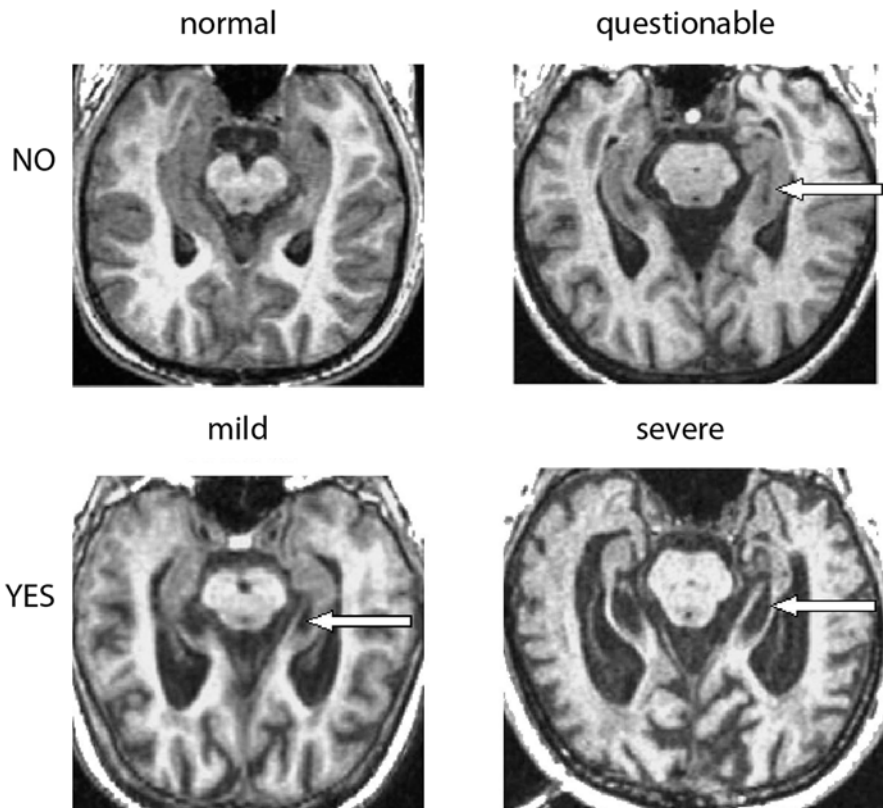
Hippocampal atrophy rating scale as shown on MRI (de Leon et al. 1993, as derived from de Leon et al. 1989)
